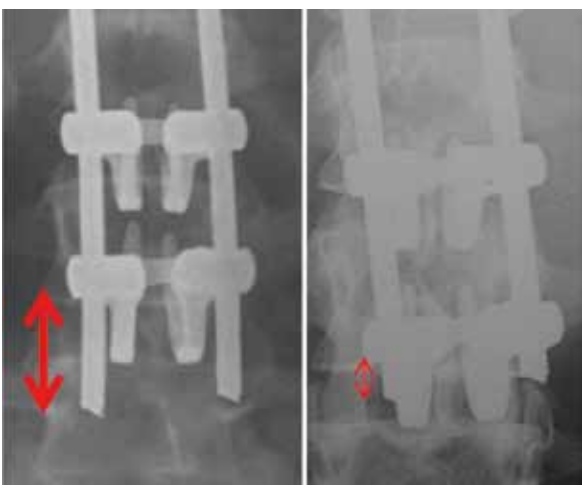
AP X-ray after operation (left) and before second operation (right) (4 years difference)
